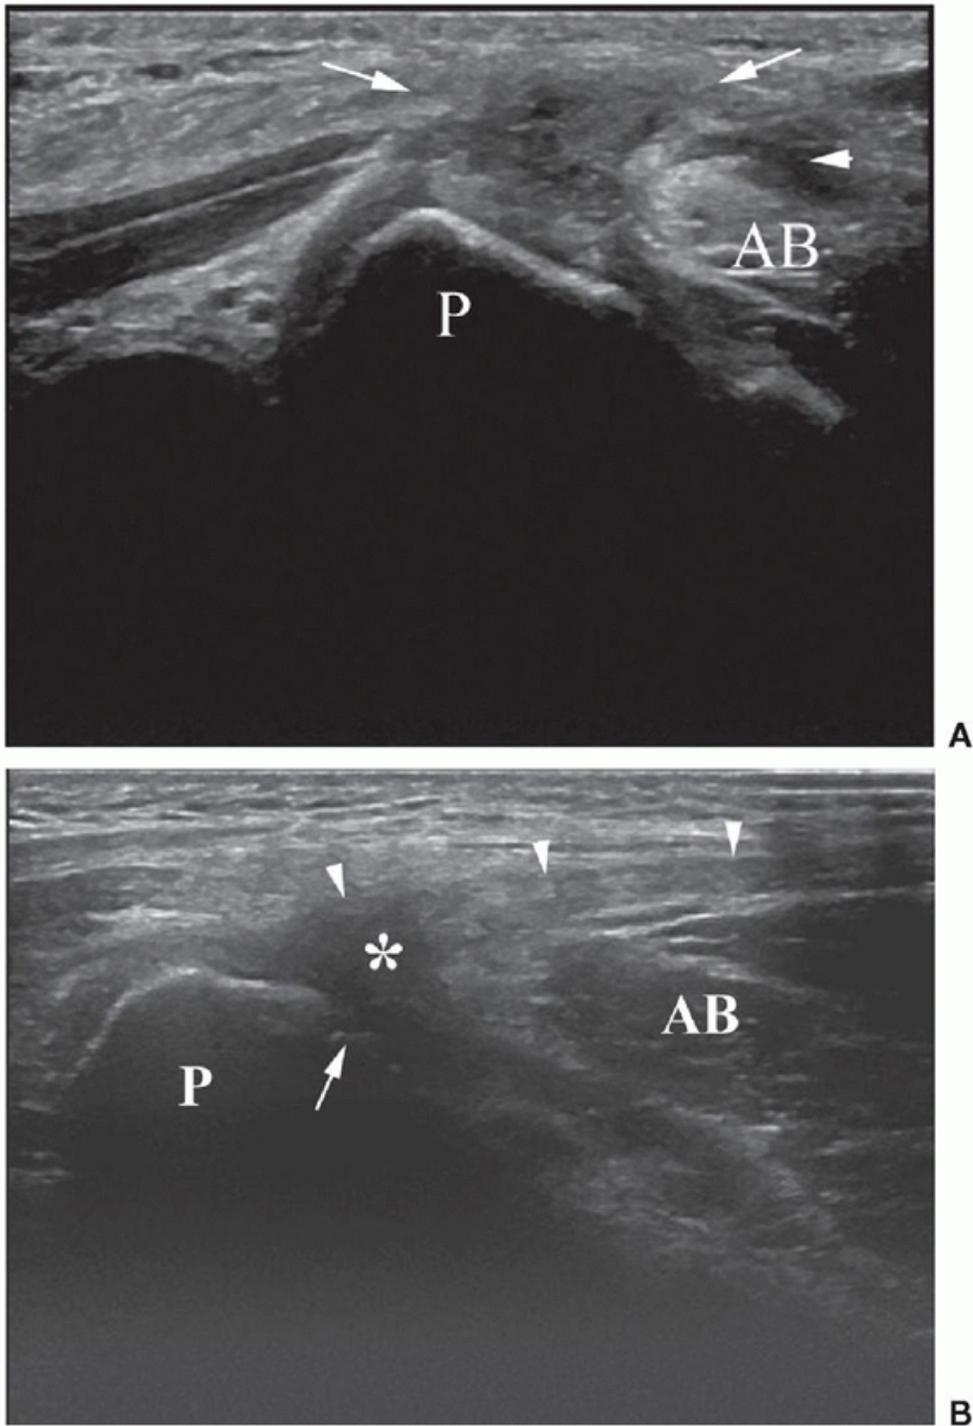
Adductor origin abnormality. A: Transverse sonogram shows acute hematoma (arrows) at the junction of the capsular and adductor tendon attachment. The edema extends into adductor brevis (AB) consistent with an acute tear; pubis (P). B: Longitudinal sonogram shows hypoechoic tendinopathy of the adductor longus origin (asterisk) with normal adductor brevis muscle (AB). Compared to (A) there is no acute change or swelling with a normal contour and more distal tendon (arrowheads). Pubis (P) cortical irregularity (arrow) is normal.
